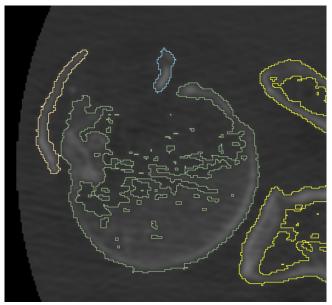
Transverse Computed Tomography image of proximal humerus with greater tuberosity fracture in 3D Slicer. (Scapula colored yellow is not used for calculations).
